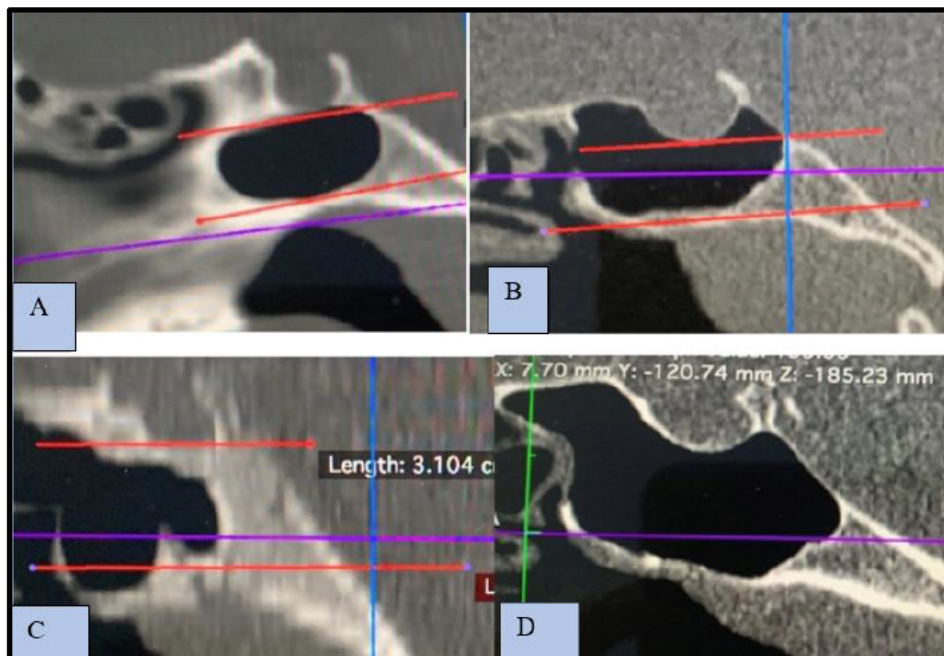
Sagittal CT scans showing different types of Posterior extensions of SS.
